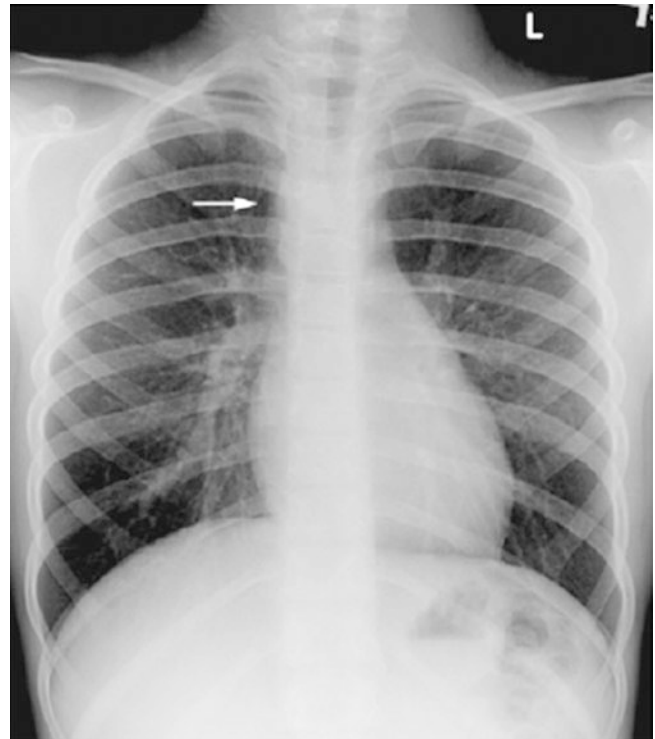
Frontal radiograph of chest demonstrating tracheal narrowing due to right aortic arch (*arrow*)
